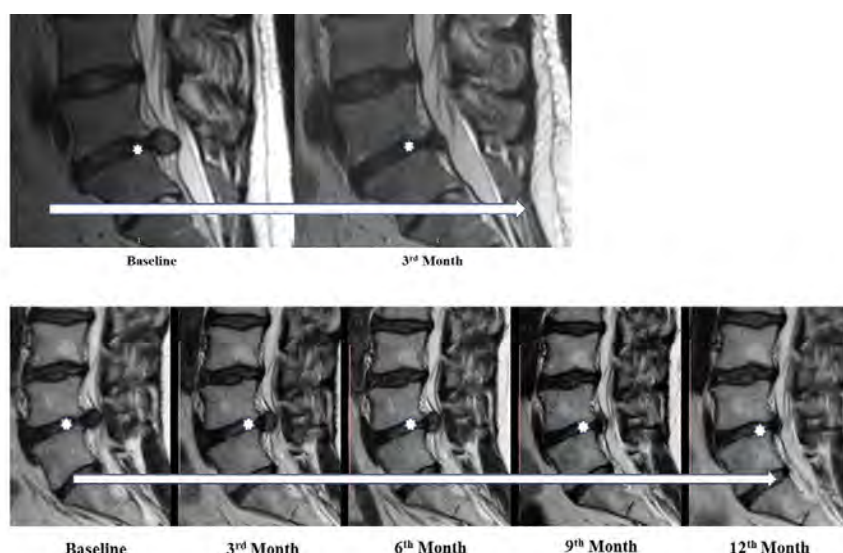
Sagittal T2-weighted MRIs of the lumbar spine noting (top) early disc herniation resorption in a 41-year-old male and (bottom) late resorption in a 36-year-old female. Asterisk denotes level of the disc herniation. The arrow depicts the progression of the imaging from earliest (left) to latest follow-up (right). Note, first MRI was taken at baseline and each subsequent MRI at each 3-month follow-up interval until asymptomatic.
